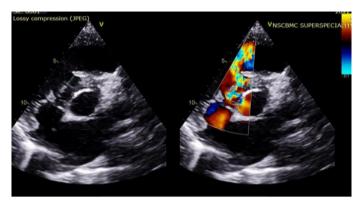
Preoperative ECHO (parasternal short axis view) showing perimembranous VSD with aortic valve prolapse and color flow across the VSD
